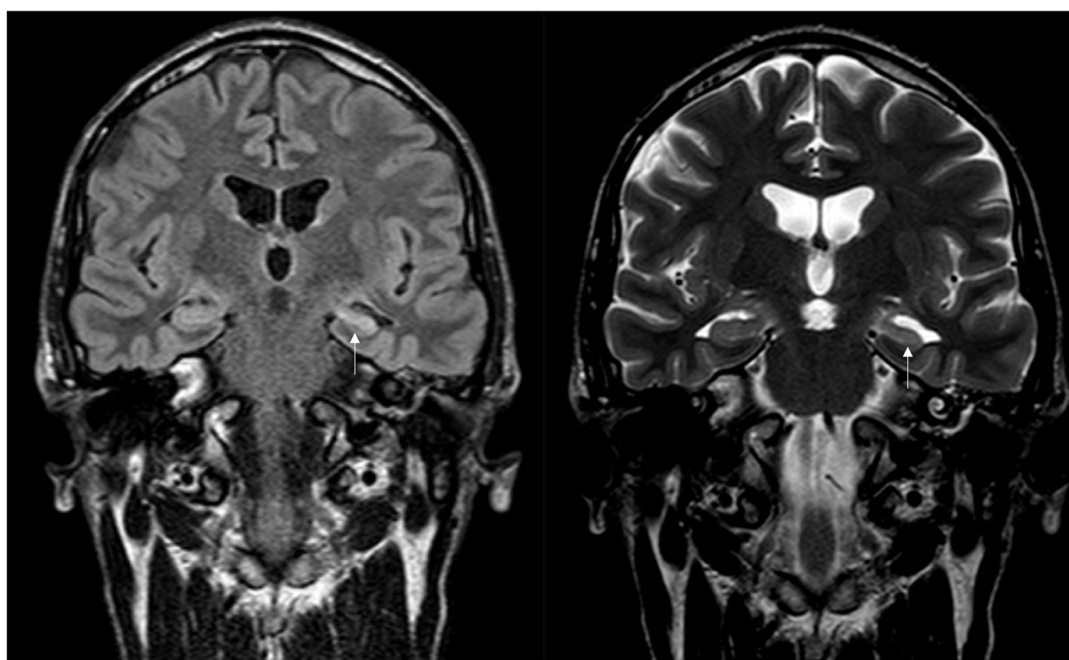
Brain MRI showing left hippocampal sclerosis (white arrow) on FLAIR and T2-weighted sequences on coronal slices.
